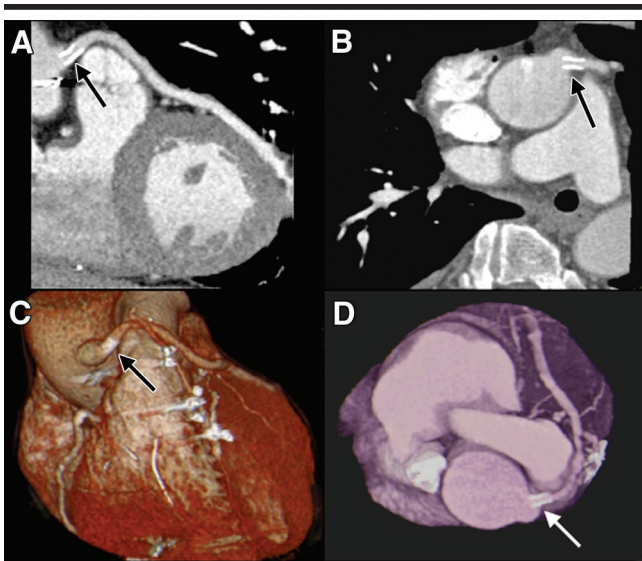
Coronary artery bypass graft stent patency at four-detector row CT. *A*, Craniocaudal curved multiplanar reconstruction, *B*, straight oblique transverse multiplanar reconstruction, *C*, uncropped anterior reconstruction, and *D*, cranially cropped volume-rendered surface reconstruction in the same patient as in Figure 4 demonstrate a widely patent stent (arrows) traversing the previously shown stenosis of the proximal portion of aortocoronary venous graft to the middle left circumflex coronary artery.
